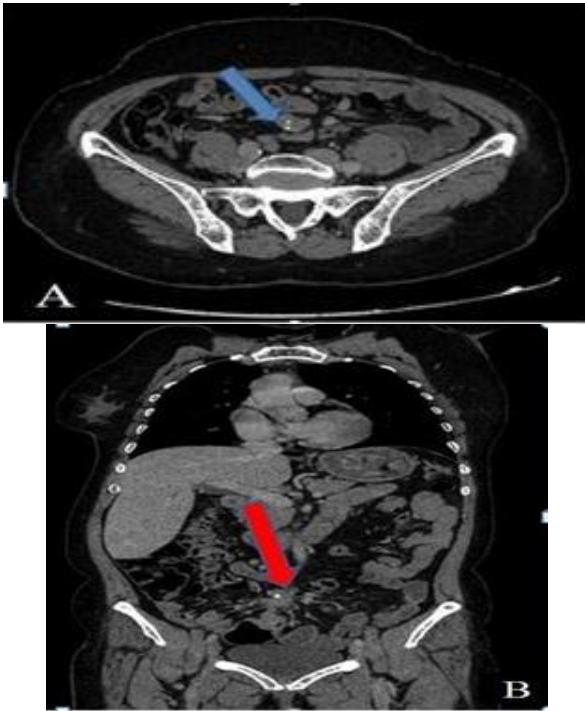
A: Axial abdominal computed tomography showing endoluminal ileal mass in the right iliac fossa, B: Axial image showing retractile mesenteritis
